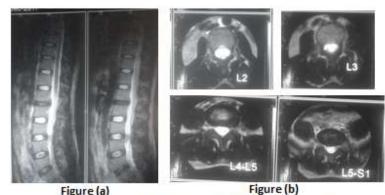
Figure (a) Figure (b) Figure (a) and (b): T2 weighted thoraco lumbar MRI imaging detected an subdural hematoma extending from 2<sup>nd</sup> lumbar to 2<sup>nd</sup> sacral vertebra
